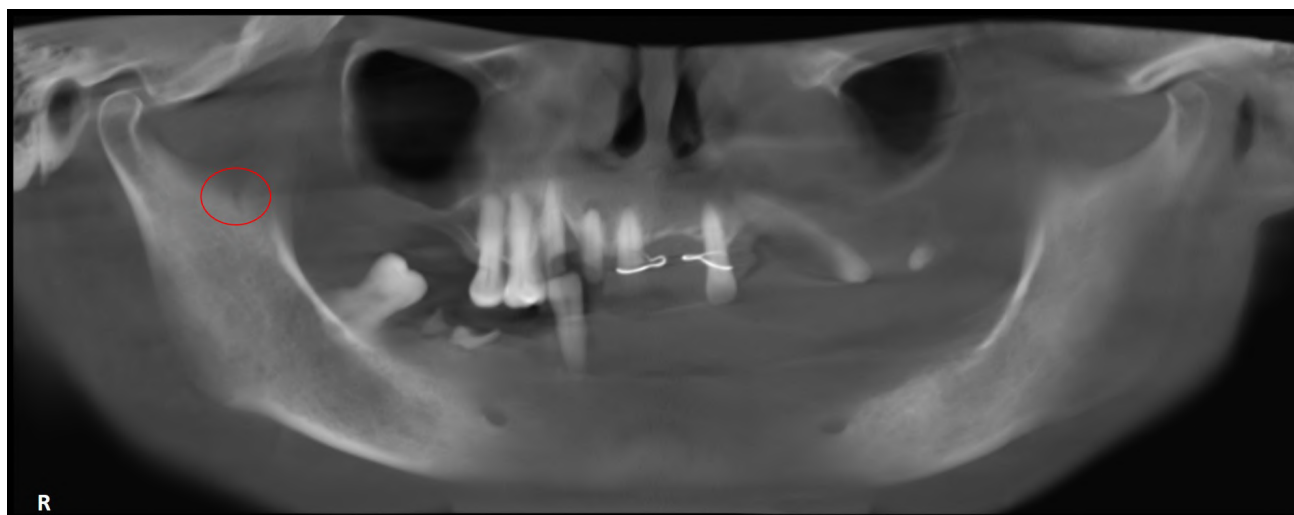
Presence of coronoid foramen in the orthopantomogram.
